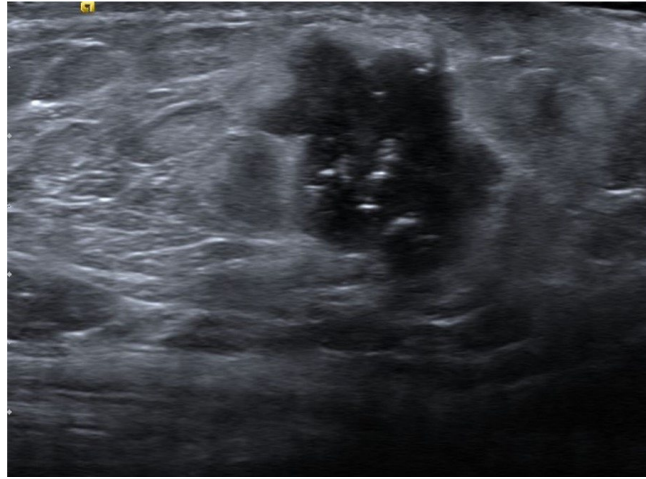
Ultrasound showing a parallel mixed echogenicity mass. This is representative of a mass similar to this patient's case but is not the patient in question. Case courtesy of Zaki Zaheer, Radiopaedia.org, rID:92968.
